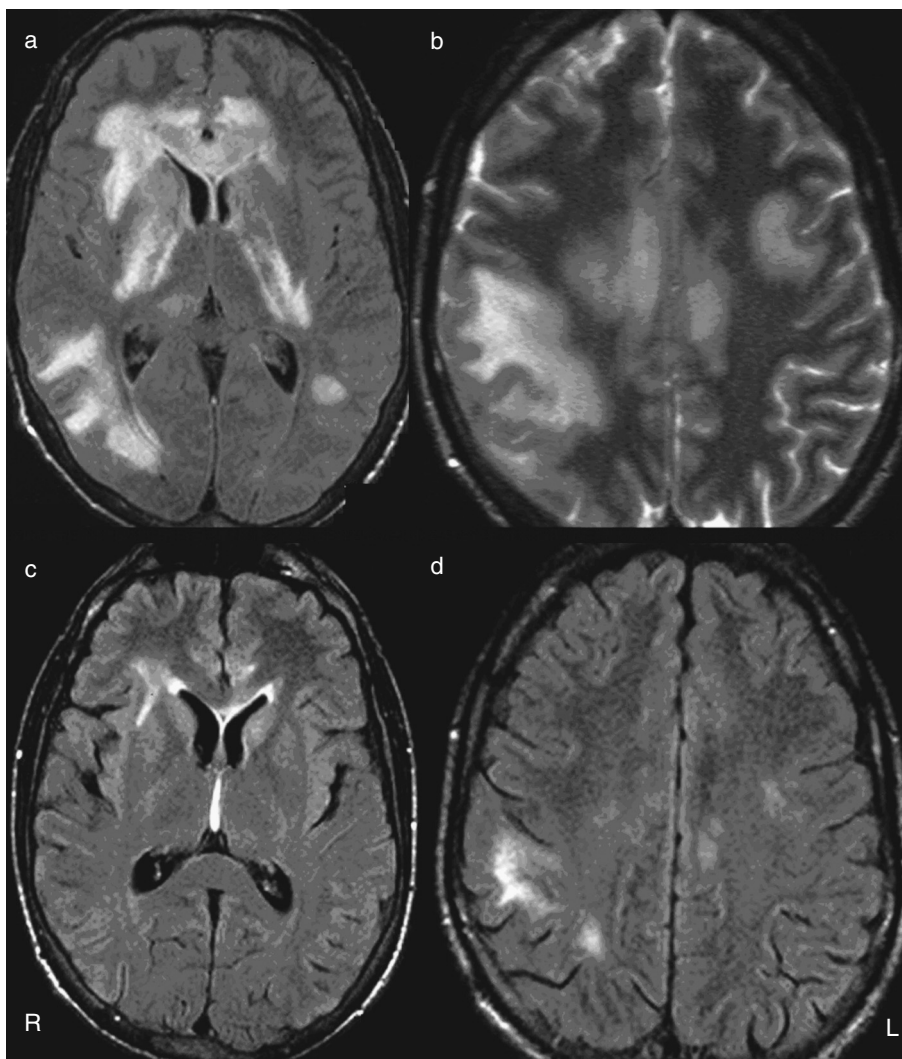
(a, b) brain magnetic resonance images (MRIs) performed on day 6. Axial fluid-attenuated inversion recovery (FLAIR) and axial T2–TSE show bilateral asymmetric confluent hyperintensity involving subcortical white matter, corpus callosum, and deep grey matter. (c, d) MRIs performed on day 18. FLAIR shows a decrease in lesion load.
